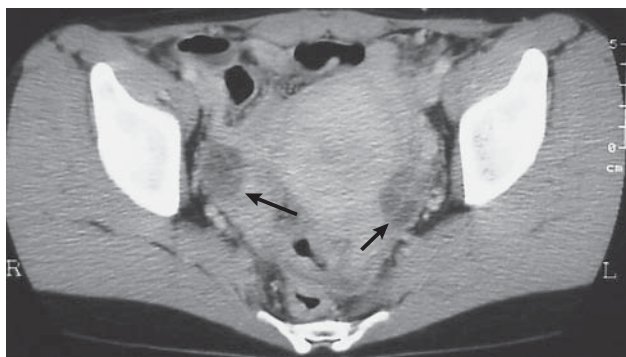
Contrast-enhanced computed tomography scan image of the pelvis shows enlargement of the uterus and bilateral swelling of the fallopian tubes (arrows).
